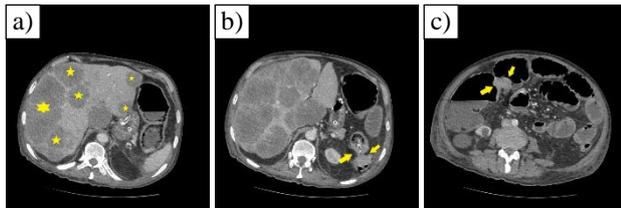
On the axial view of computed tomography, there were; a) multiple metastatic foci in the liver (yellow asterisks), b) a totally-obstructive tumoral mass at the level of the splenic flexure, and c) the hepatic flexure (yellow arrows)
